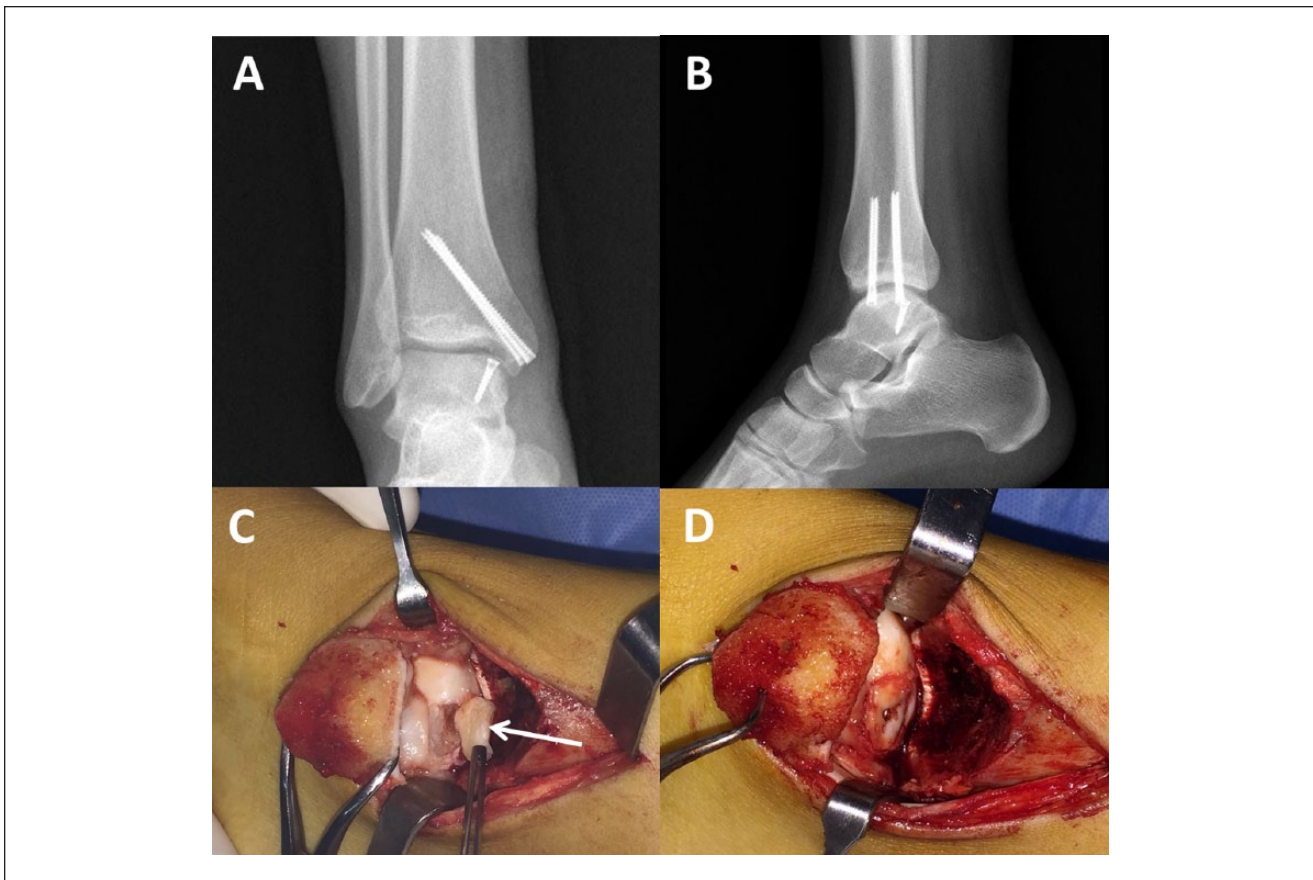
Open reduction and internal fixation of an OLT. (A and B) Postoperative radiographs. To reach the site of the lesion, a medial malleolus osteotomy was performed and then fixed with screws. (C) Intraoperative view of the lesion showing a chondral fragment (arrow). (D) Fragment reduction was completed with a metallic screw concealed in the cartilage layer.
